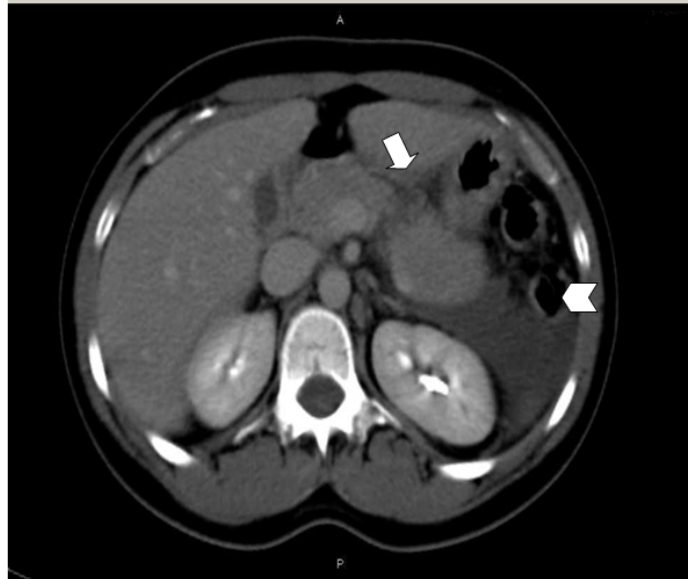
Contrast enhancement CT revealed pancreatic fracture resulting from go-kart accident
